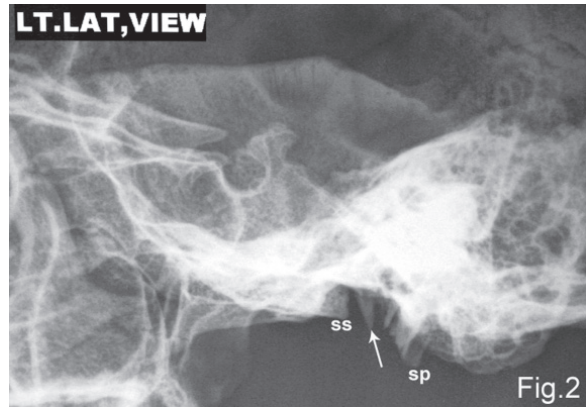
Left lateral view of a radiograph of the infratemporal region showing the osseous structures. The white arrow shows the spinous projection of the temporal bone; ss — spine of the sphenoid, sp — styloid process.
